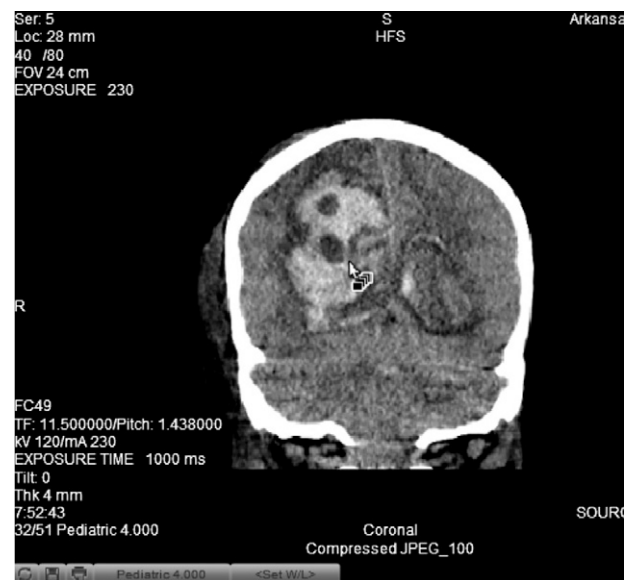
Stat head CT was performed, which showed large right parenchymal hematoma (5 cm) with intraventricular decompression and evolving acute hydrocephalus, effacement of sulcal spaces, sylvian fissure, basal cisterns, and crowding of posterior fossa structures with 3 cm leftward midline shift.
